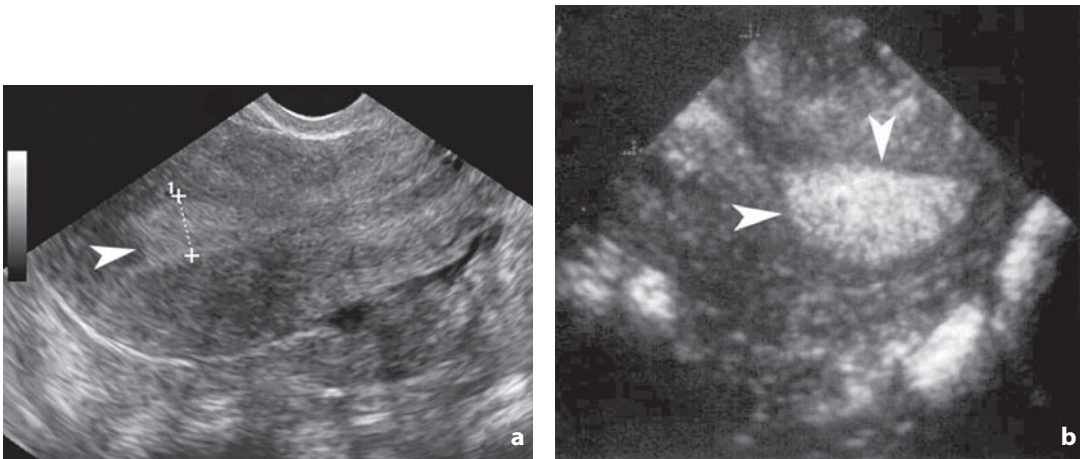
Transvaginal ultrasonography. a Longitudinal and b transverse scans. Uterus. Luteal phase. The endometrial cavity (*arrowheads*) appears broadened and hyperechoic
